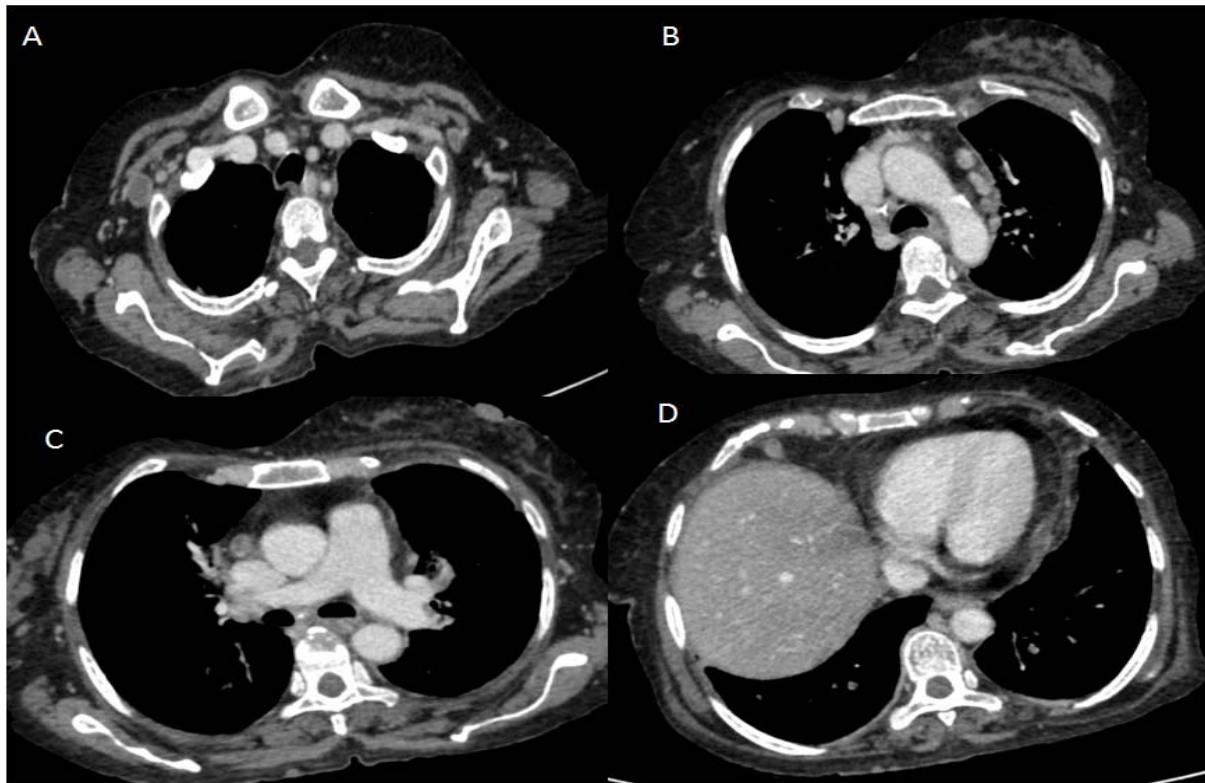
Contrast-enhanced CT scan of thorax showing lymph nodes in right axilla (A), in prevascular space (B,C), and the right juxtadiaphragmatic region (D) showing peripheral enhancement with central hypodense areas of necrosis.
